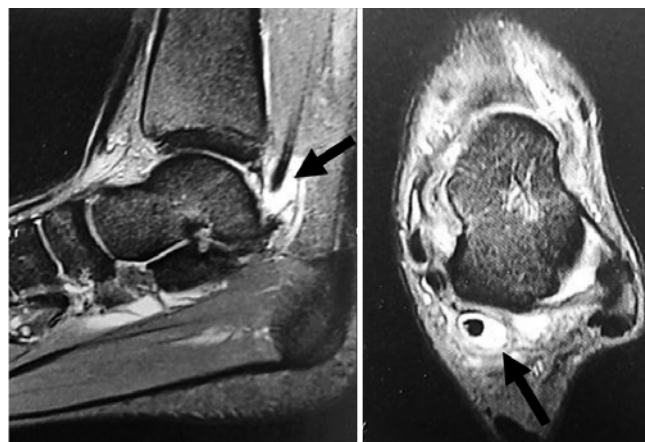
A 24-year-old female dancer diagnosed with hallux saltans; the flexor hallucis longus muscle synovitis on magnetic resonance imaging (arrows)
